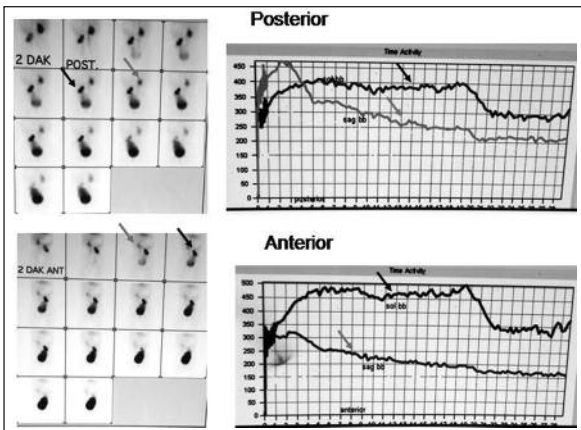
Top: Posterior dynamic views of simultaneous anterior-posterior DRS and posterior renograms of another patient with pelvic kidney. Bottom: Anterior views of simultaneous anterior-posterior dynamic renal scintigraphy and anterior renograms. Gray arrows display the normal located right kidney and black arrows show the pelvic kidney. Anterior renogram of the pelvic kidney shows the renal functions better than the posterior renogram of this particular kidney. Similarly, posterior renogram of the normal located right kidney displays the kidney's renal function better than its anterior renogram.
